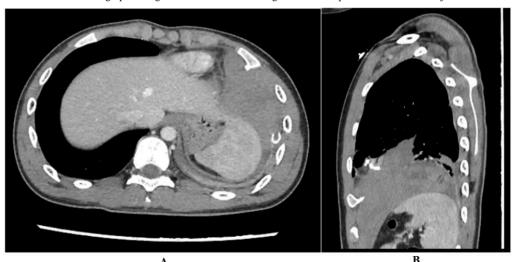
Contrast enhanced CT thorax in A) axial and B) sagittal views, showing a bony spur at left 5th anterior rib, pointing posteriorly. Left hemothorax with adjacent consolidation.
